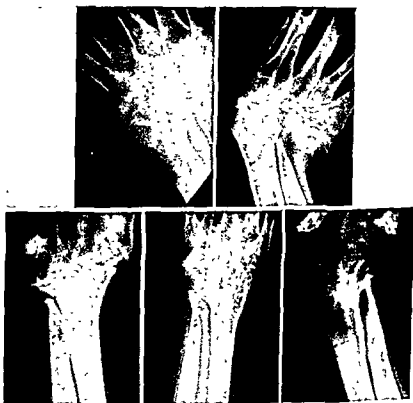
Roentgenograms of wrist joints of five patients with long standing rheumatoid arthritis. In four of these patients the opera-glass hand syndrome was present.
